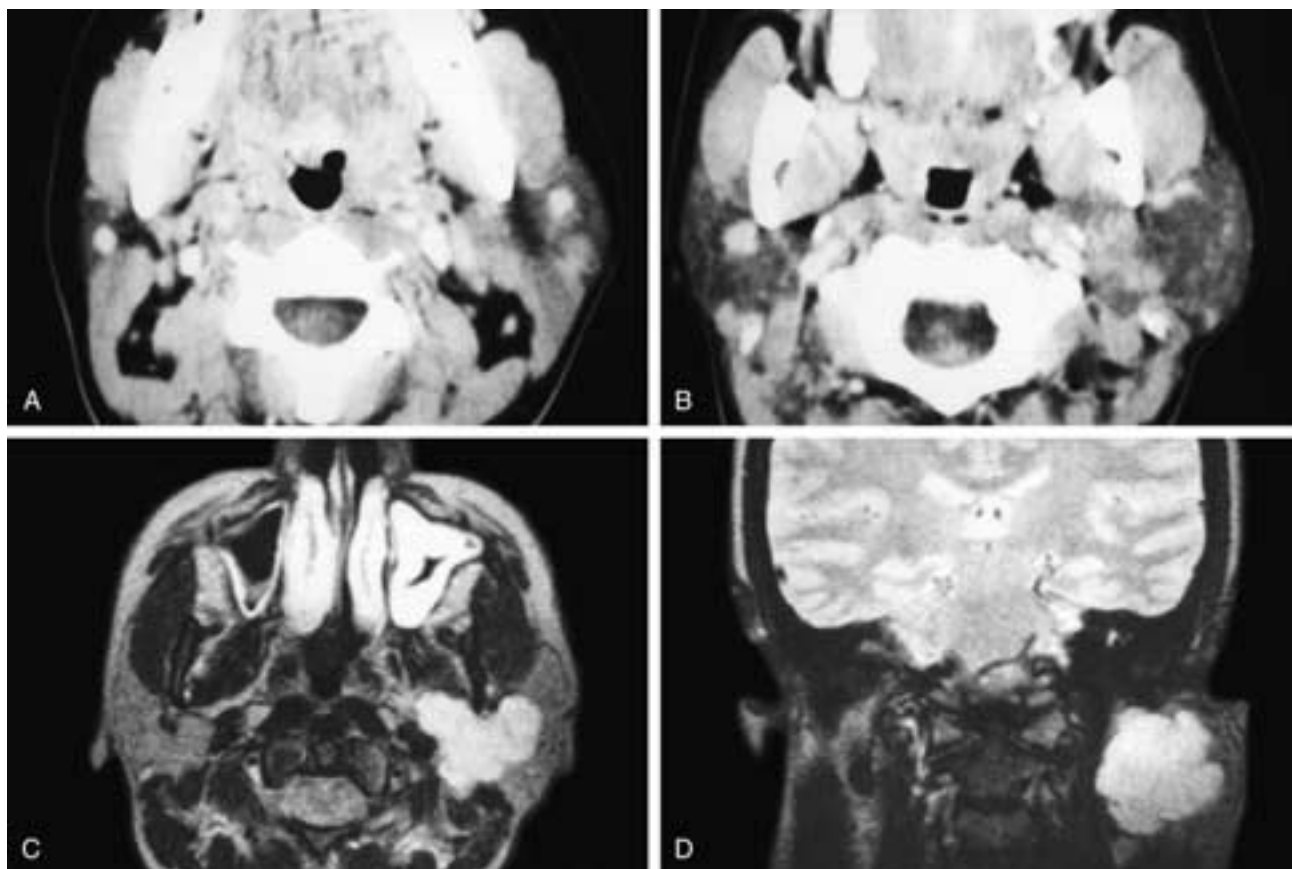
Axial contrast-enhanced CT scans (A, B) show a vaguely delineated mass in the deep portion of the left parotid gland. Axial (C) and coronal (D) T2-weighted MR images on the same patient show a lobulated solitary mass in the left parotid gland. The lesion is far better seen than on the CT scans. This patient had a pleomorphic adenoma.
